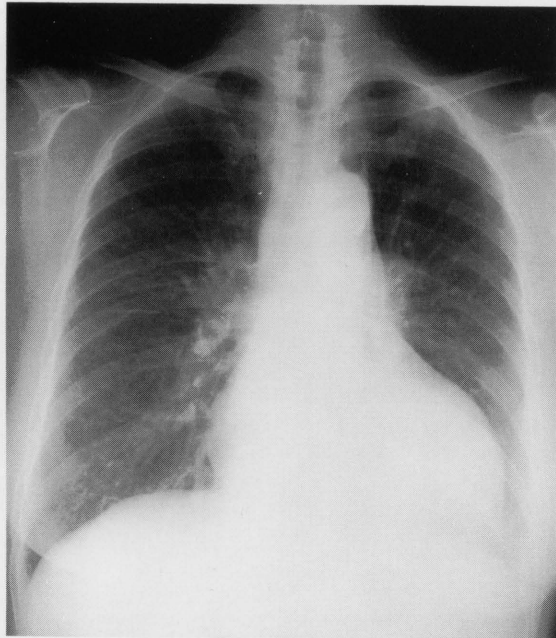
Chest X-ray. The upright posteroanterior chest roentgenogram obtained before administration of corticosteroid shows mild pulmonary congestion and marked cardiomegaly. Hilar areas were indistinct due to cardiomegaly.
